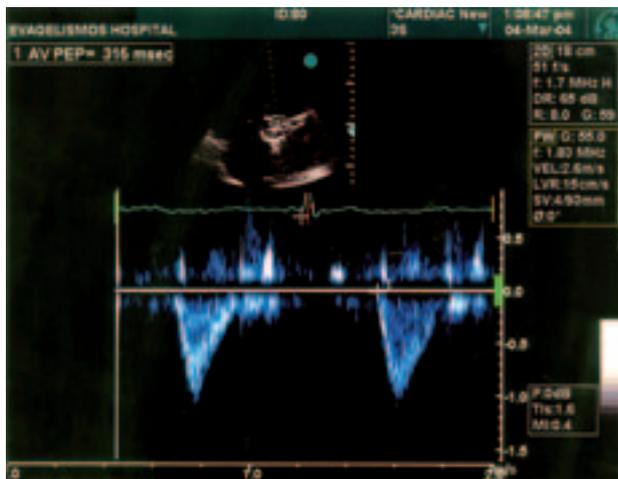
Patient with a particularly prolonged left ventricular pre-ejection period (315 ms), which is an index of significant interventricular dyssynchrony. The pre-ejection period was measured as the interval from the onset of the QRS to the onset of aortic flow (start of the aortic flow envelope on pulsed Doppler). AVPEP – aortic valve pre-ejection period.
